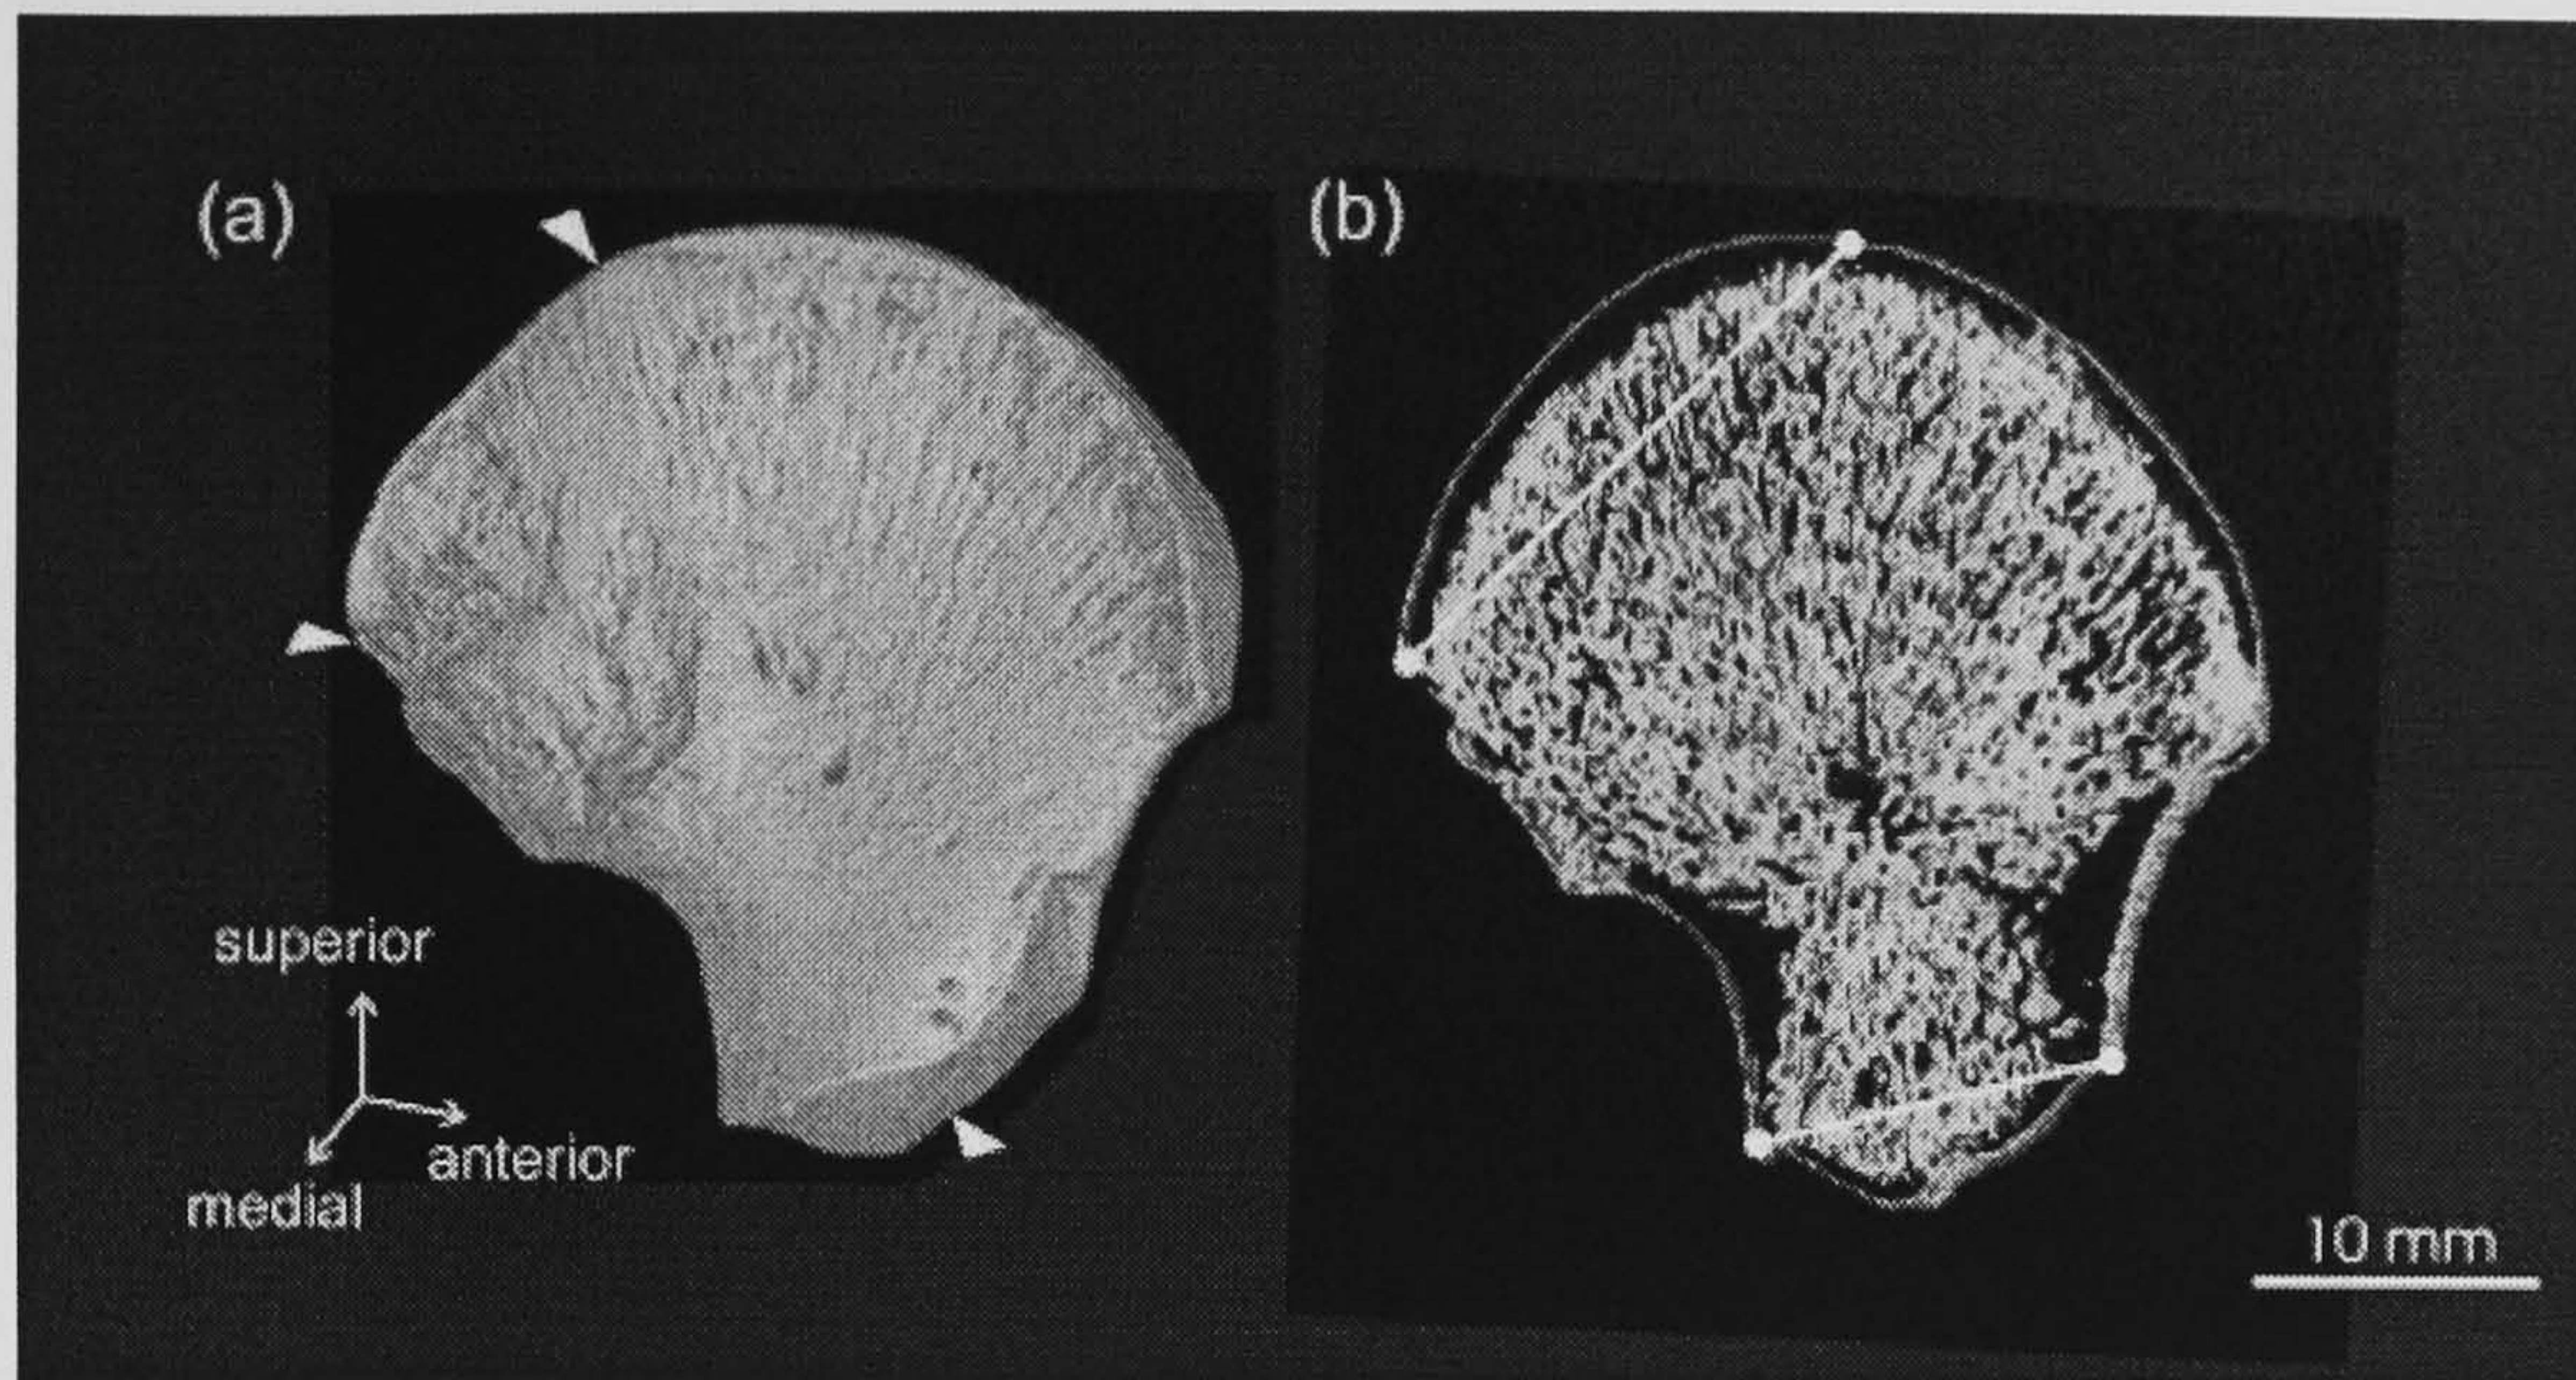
Reconstruction of a fetal ilium from CT slices (a). Triangles denote the landmarks used to define the plane of sectioning. In b, a thin slice through the ilium is shown as well as the transects used for obtaining Tb.Th. measurements.
